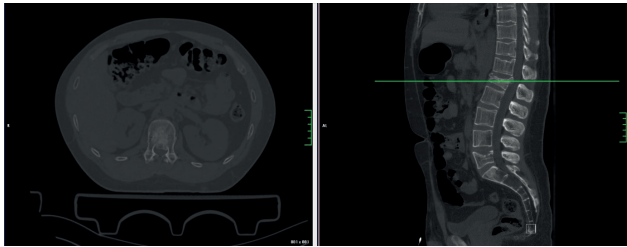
Axial and sagittal reformatted CT images reveal loss of vertebra height due to burst fracture in L1 vertebra corpus and narrowing of spinal canal.
